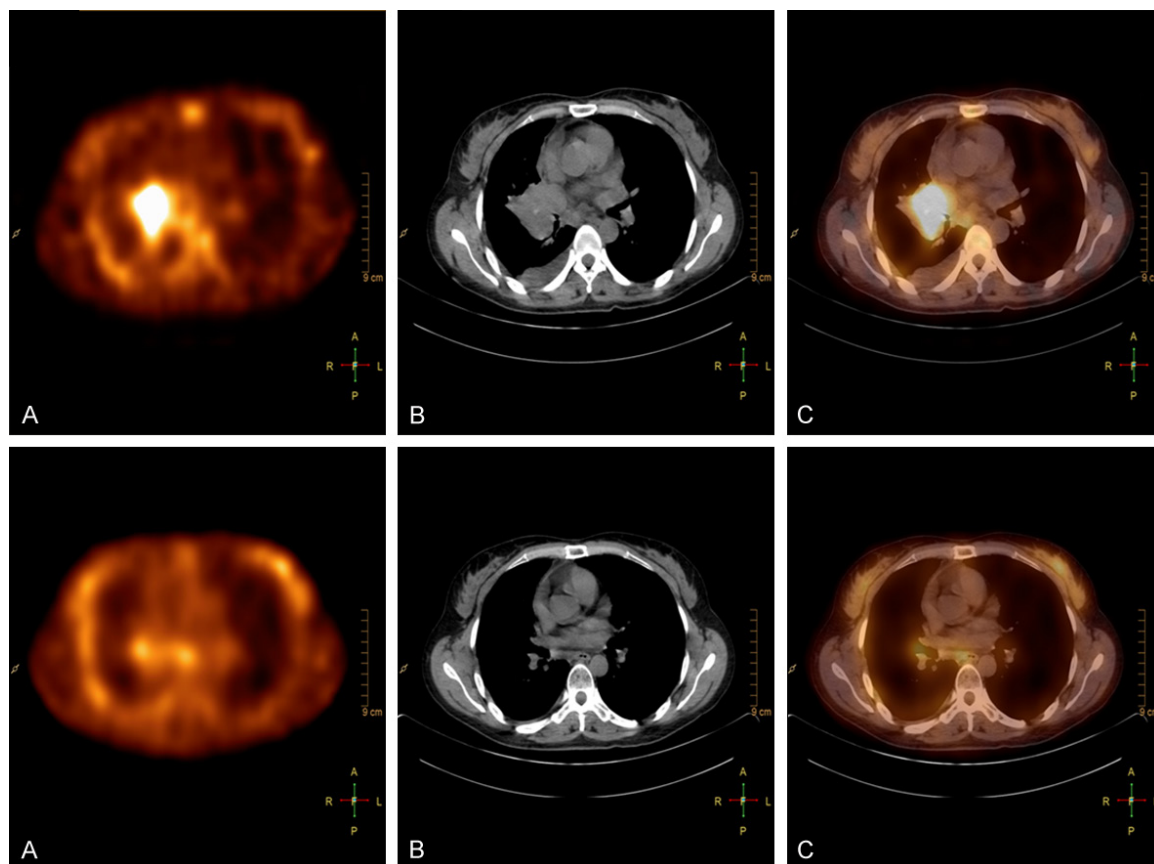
Example of a mNP patient. Non-progressive patient with right upper lobe NSCLC. (A) SPECT, (B) CT and (C) fusion images. The T/N ratio was 5.24 and 2.91 for SPECT₁ (up) and SPECT₂ (down), respectively. Based on a Δ T/N ratio cut-off value of 24.4%, the patient was classified as mNP, in accordance with RECIST evaluation on CT scan (performed 58 days after starting bevacizumab).
